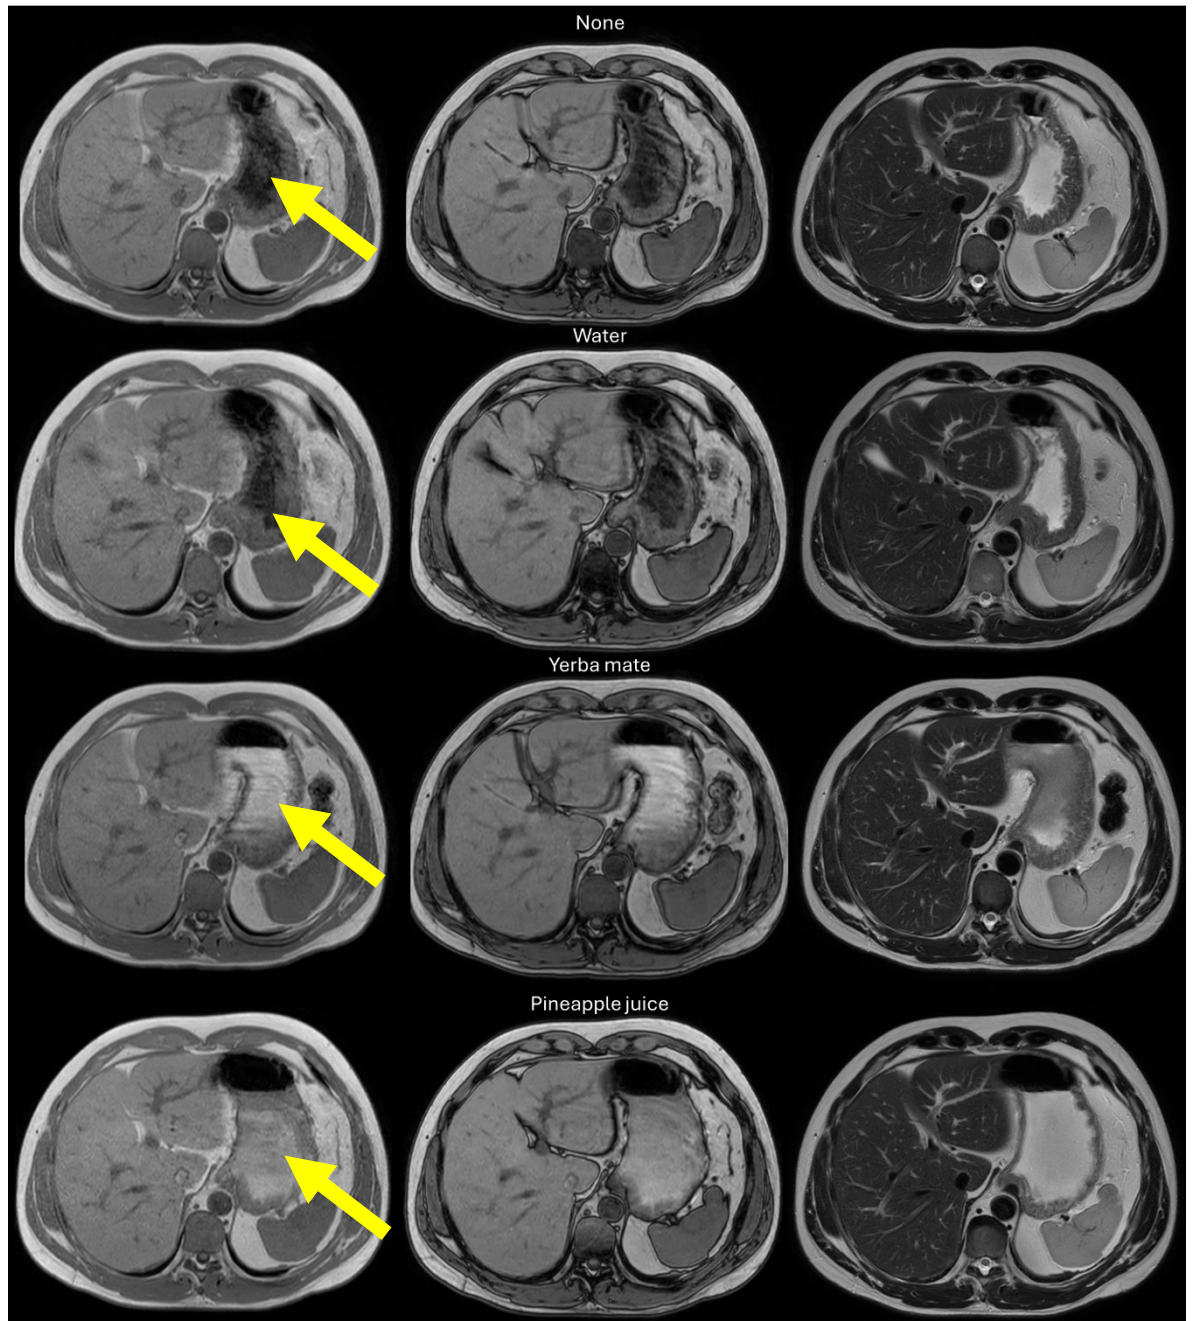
Axial MR images from a single participant (M206) demonstrating the effect of the four NMOC conditions on GI signal intensity.
